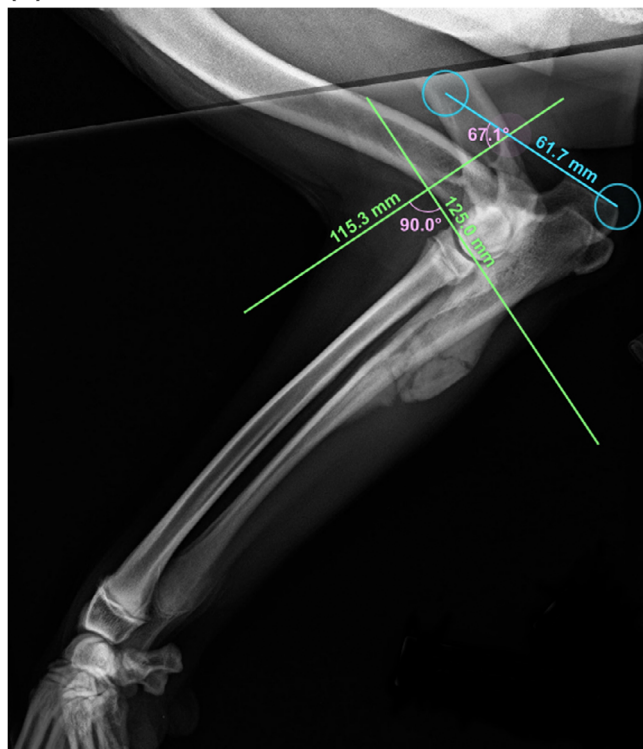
(A) Measurement of the immediate postoperative proximal ulnar angle (initial proximal ulnar angle) on the superimposed radiographs using the proximal radial joint orientation line as a reference point. (B) Measurement of the 6–8 week postoperative proximal ulnar angle (follow-up proximal ulnar angle) on the superimposed radiograph using the proximal radial joint orientation line as a reference point.
